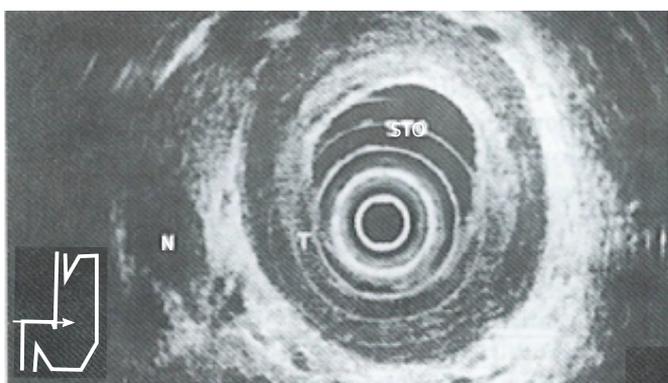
Endoscopic ultrasonography-T₃ cancer. Endoscopic ultrasonography findings in linitis plastica. Hypoechoic diffuse wall thickening is shown, with preservation of layers as distinctive structures. Note invasion of all layers but absence of invasion of adjacent organs.
